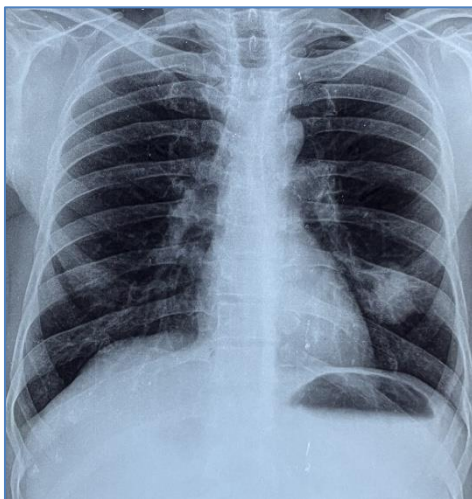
Chest x-ray PA showing coin lesion or round opacity in left lower zone
